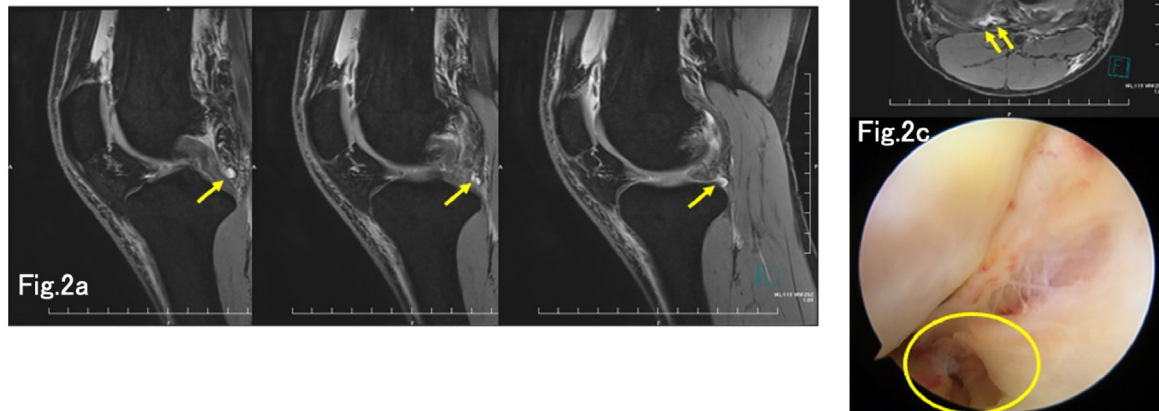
Case 1; 19-year-old male. (a) Magnetic resonance imaging of a ramp lesion (RL) (arrow) in the sagittal plane. (b) An RL (arrow) in the axial plane. The RL can be easily identified by either slice. (c) Intraoperative right knee meniscal ramp lesion (circle) around the medial posterior horn of this case.
